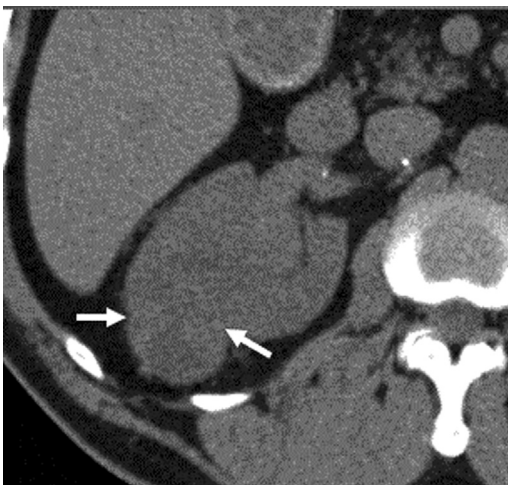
Unenhanced axial CT image demonstrating poorly defined ccRCC. Although some portions measure less than 20 HU, there are areas of heterogeneous higher attenuation (arrows).
